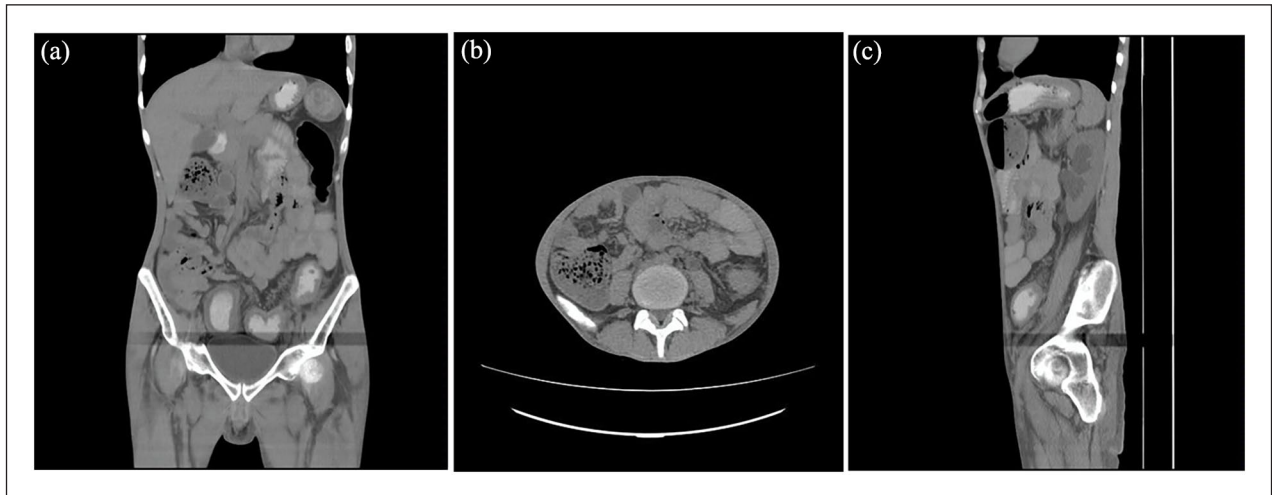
CT abdomen and pelvis with contrast showing circumferential intestinal wall thickening, mural stratification, extramural deposition of fat, and stricture though not widely appreciated. (a) Coronal plane. (b) Axial plane. (c) Sagittal plane.
